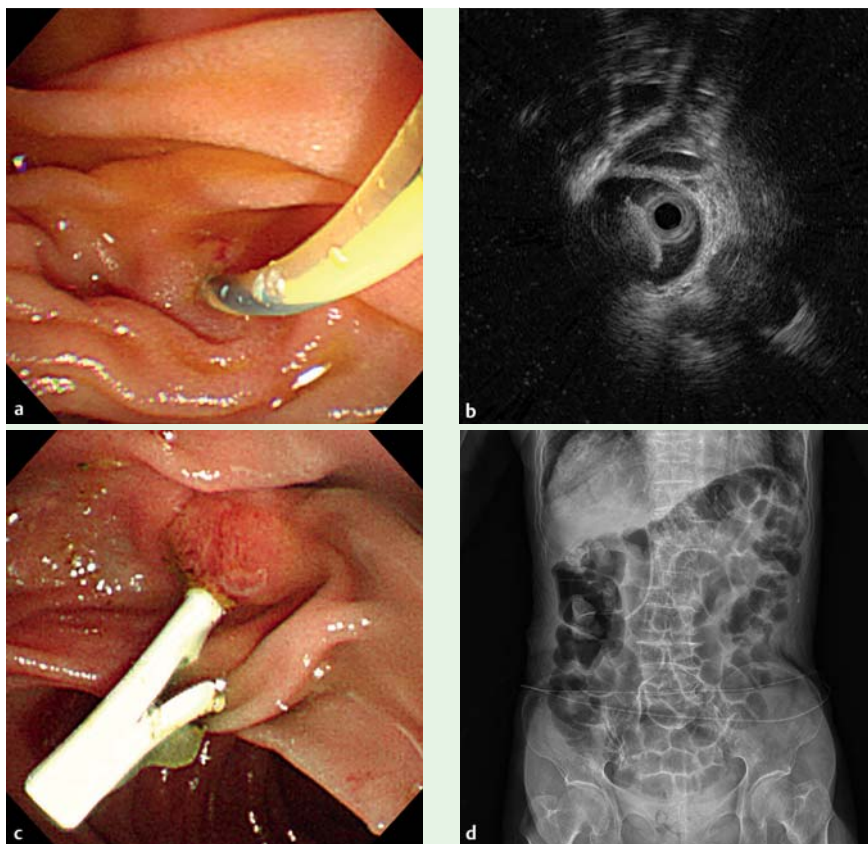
Intraductal ultrasonography (IDUS)-directed endoscopic retrograde biliary drainage (ERBD) without fluoroscopy. a Bile aspiration after biliary cannulation. b IDUS views of a stone in the common bile duct. c Placement of stent for ERBD using IDUS without fluoroscopy. d Plain abdominal radiograph after ERBD insertion.
